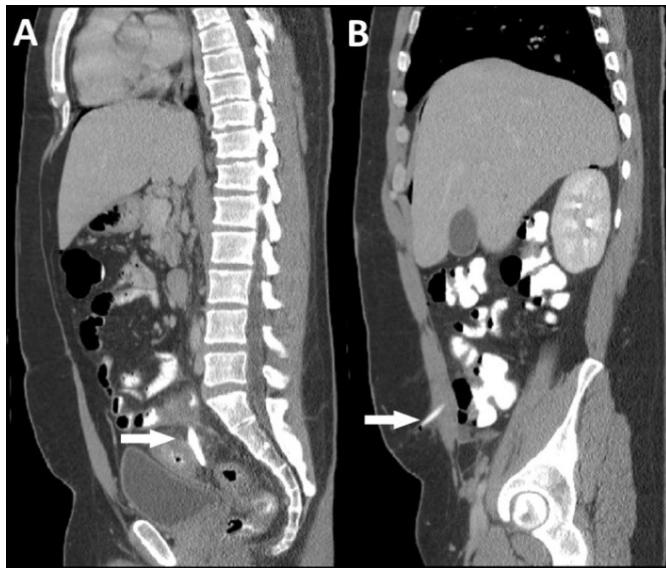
Post-operative CT after laparoscopic drainage of pericolonic abscess. Both images were obtained with only oral contrast on POD 6 (HD 13) to assess for extravasation of oral contrast through the sigmoid perforation. (A) Sagittal view of the tip of the JP drain located in the pericolonic abscess (arrow). (B) JP drain catheter exiting the abdominal wall, containing oral contrast, demonstrating continuity with enteric lumen and controlled fistulization.
